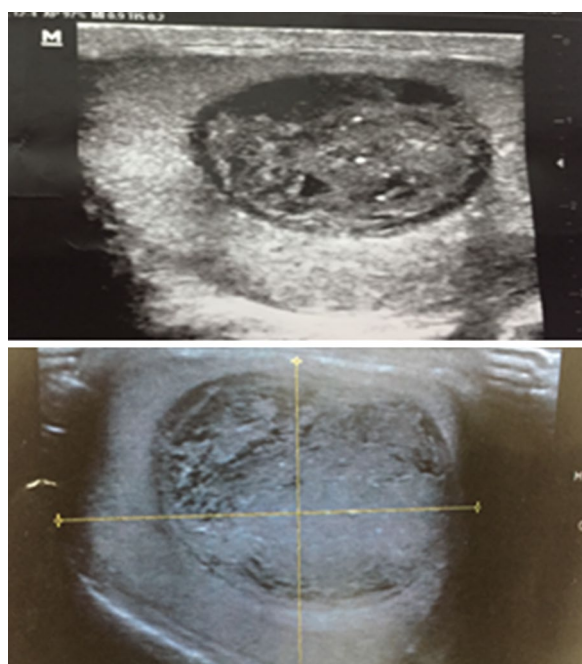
Testicular ultrasound showing a large intra-testicular mass of 65 mm
